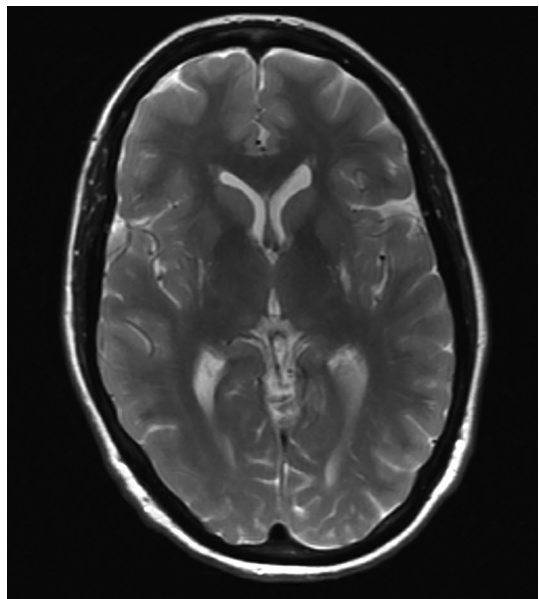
Brain MRI of case 2 (T₂ TSE) showing abnormalities of the dorsal putamen.
